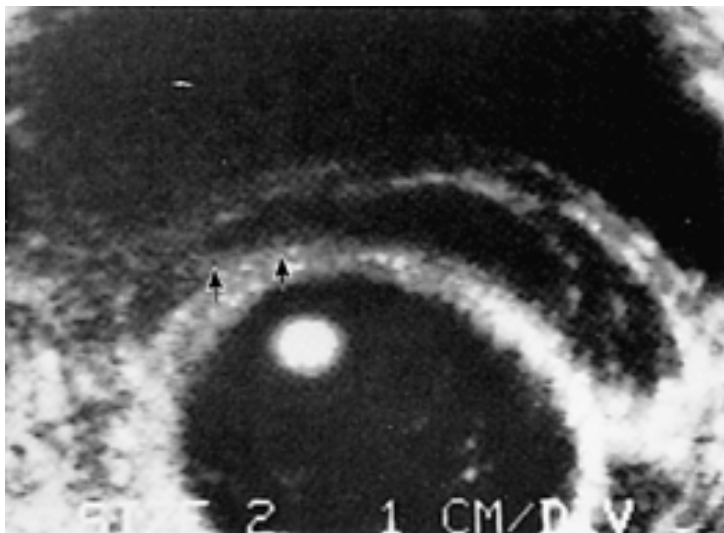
Obliteration of seminal vesicle (arrows) by invasive prostate cancer demonstrated by transrectal ultrasonography (TRUS). Such an observation should prompt a consideration of ultrasound-guided needle biopsy to confirm the presence of stage T₃ disease. (From Waterhouse RL, Resnick MI. The use of transrectal ultrasonography in the evaluation of patients with prostatic carcinoma. *J Urol* 1989;141:233, with permission.)
